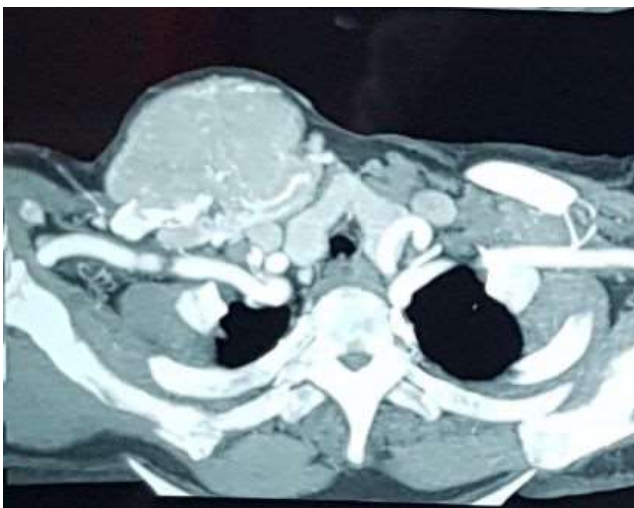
CT angiography revealing ill defined heterogeneous lesion involving vascularity.
